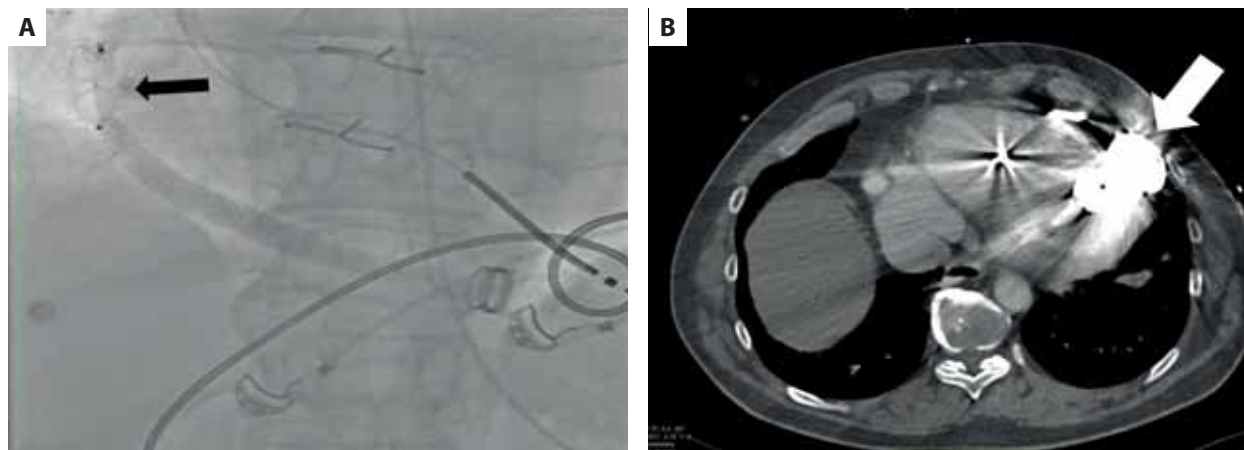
A. Angiography after implantation of the Amplatzer occluder to the left ventricular assist device outflow graft, an arrow shows the Amplatzer occluder. B. Computed tomography angiography of the aorta. An arrow shows an inflow cannula
